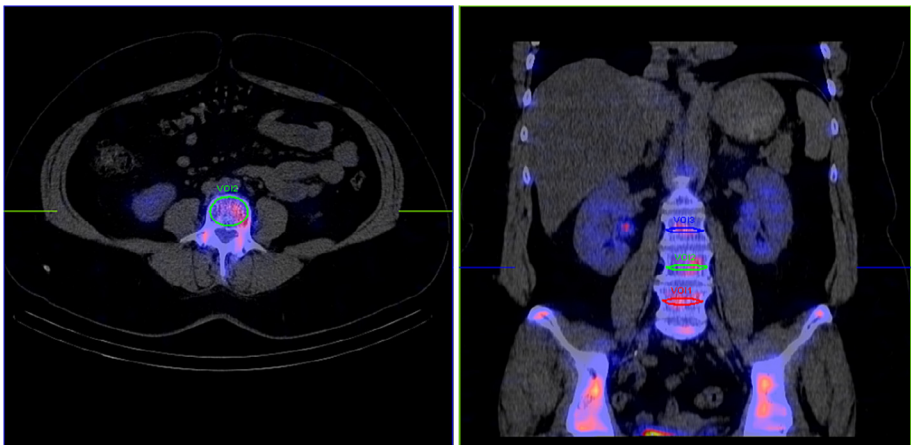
SPECT/CT image of fused sets of data (transverse and coronal) where the scan is assessing the uptake of 99mTechnetium-dicarboxypropane diphosphonate (^{99m}Tc-DPD) within the spinal column (Cachovan et al., 2013).
